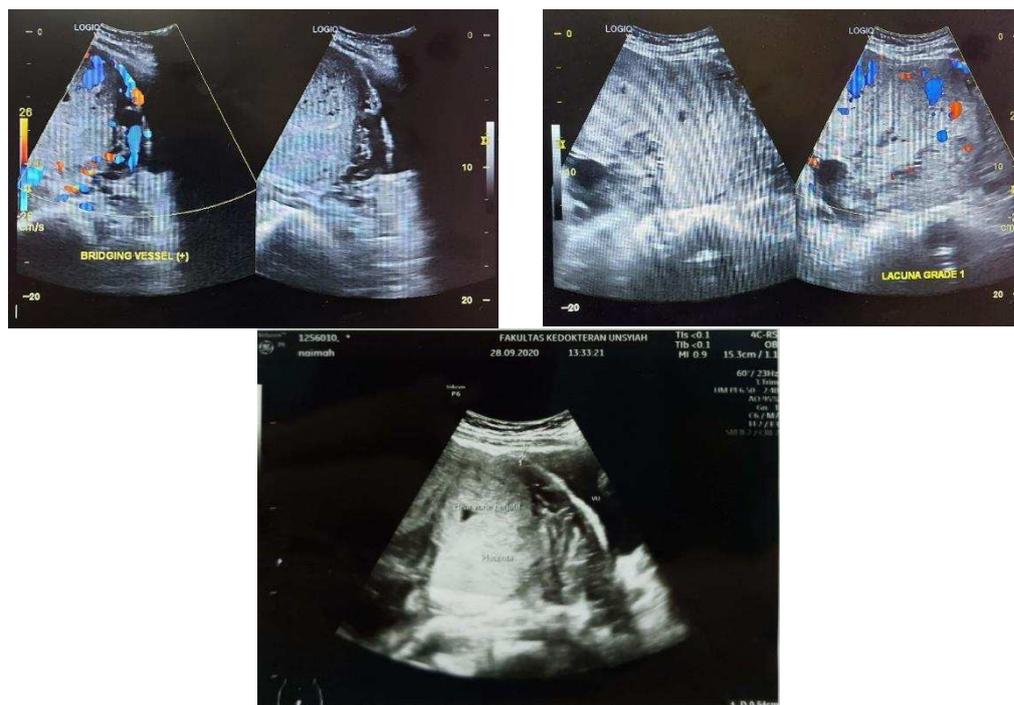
Preoperative ultrasound image
